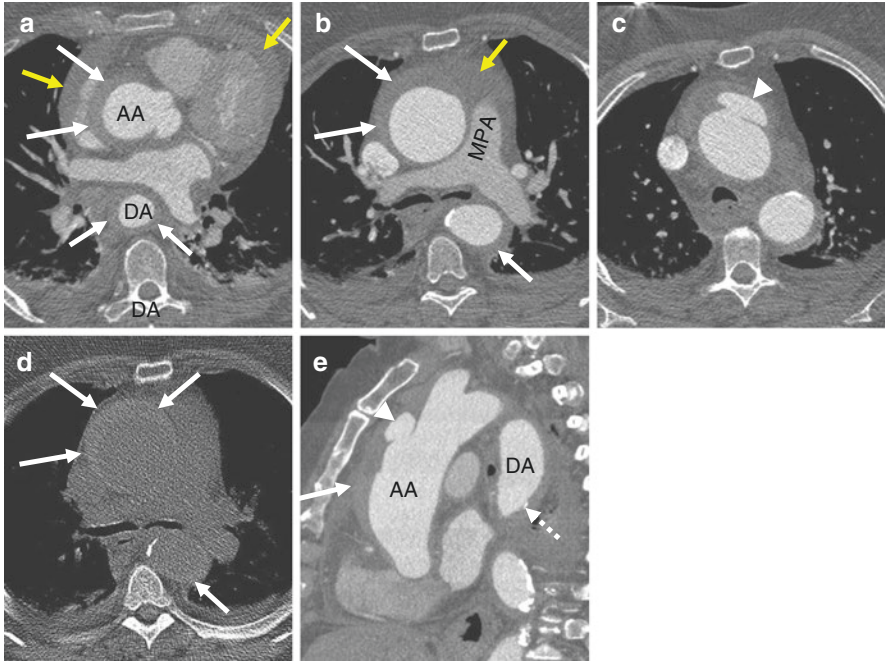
Noncontrast (d) and postcontrast (a-c, e) axial (a-d) and sagittal (e) CT images demonstrate a type A IMH in a 79-year old woman with chest pain. The noncontrast image shows a thin high-density crescent of IMH (white arrows) in both the ascending aorta (AA) and the descending aorta (DA). An ascending aneurysm is evident (52 mm). A large ulcer-like projection (ULP) arises from the anterior AA (arrowheads). Note the displaced intimal calcification in the DA (dotted arrow). Mild hemopericardium (yellow arrows) is present. MPA Main pulmonary artery
